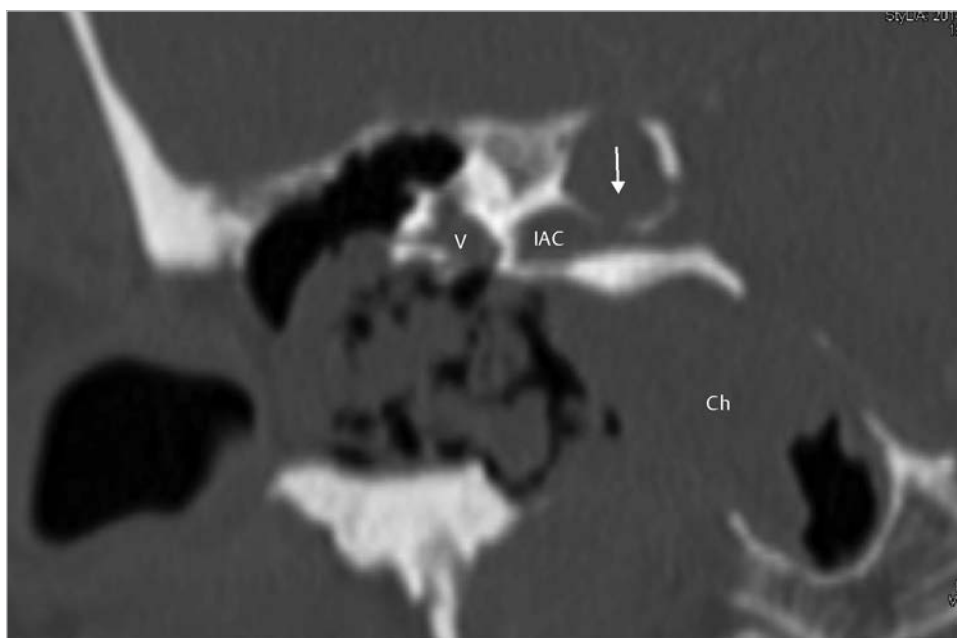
The coronal section of CT scan shows cholesteatoma (Ch) reaching the area of the clivus. The internal auditory canal is eroded (*arrow*), and a small remnant of the posterior labyrinth located just lateral to the fundus is seen. Note prominent residual of the bone covering the middle fossa that limits access to the deep area. Ch, cholesteatoma; IAC, internal auditory canal; V, vestibule.
